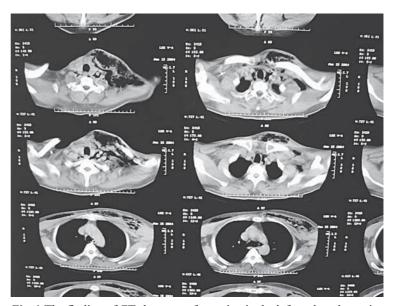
The finding of CT shows gas formation in the left neck and anterior chest
